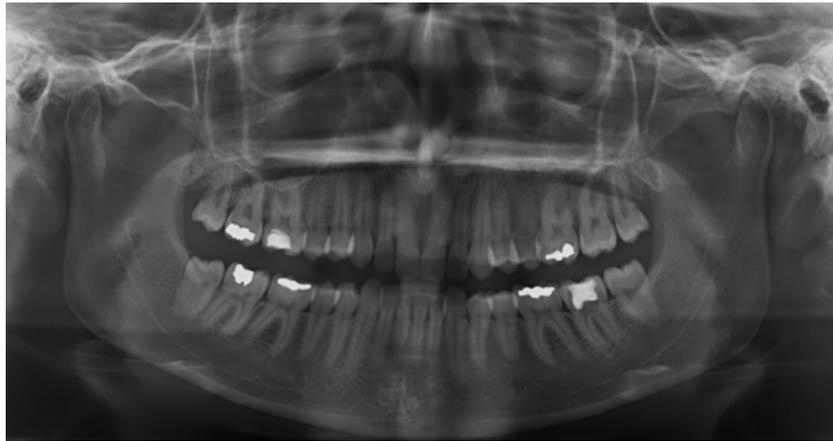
Initial panoramic radiography.
